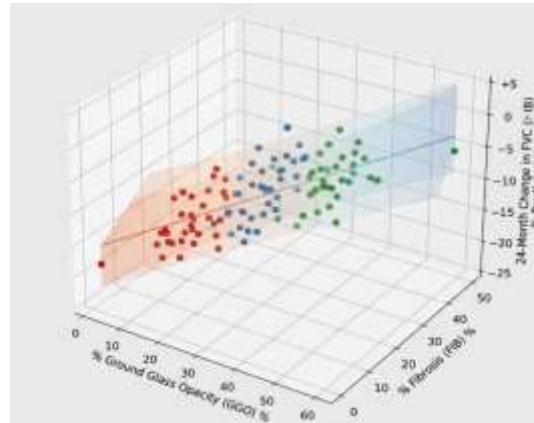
Three-Dimensional Relationship Between HRCT Metrics and Functional Decline
